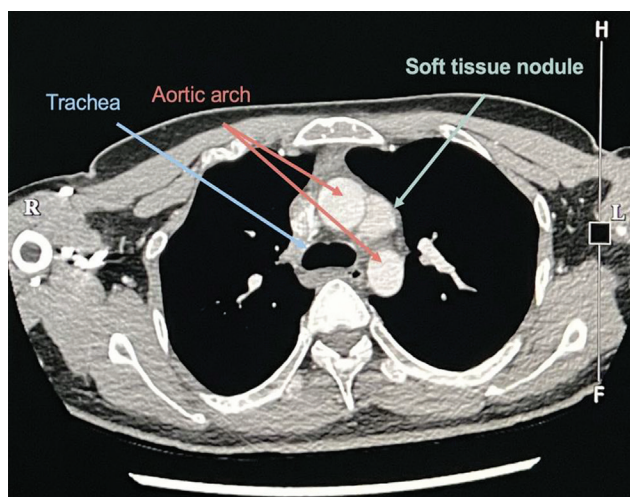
Axial contrast-enhanced CT image shows an enhancing soft tissue nodule in the aortopulmonary window (labelled) consistent with an ectopic parathyroid adenoma. This corresponds to the focus of tracer uptake detected on the Tc-99m sestamibi scan.
